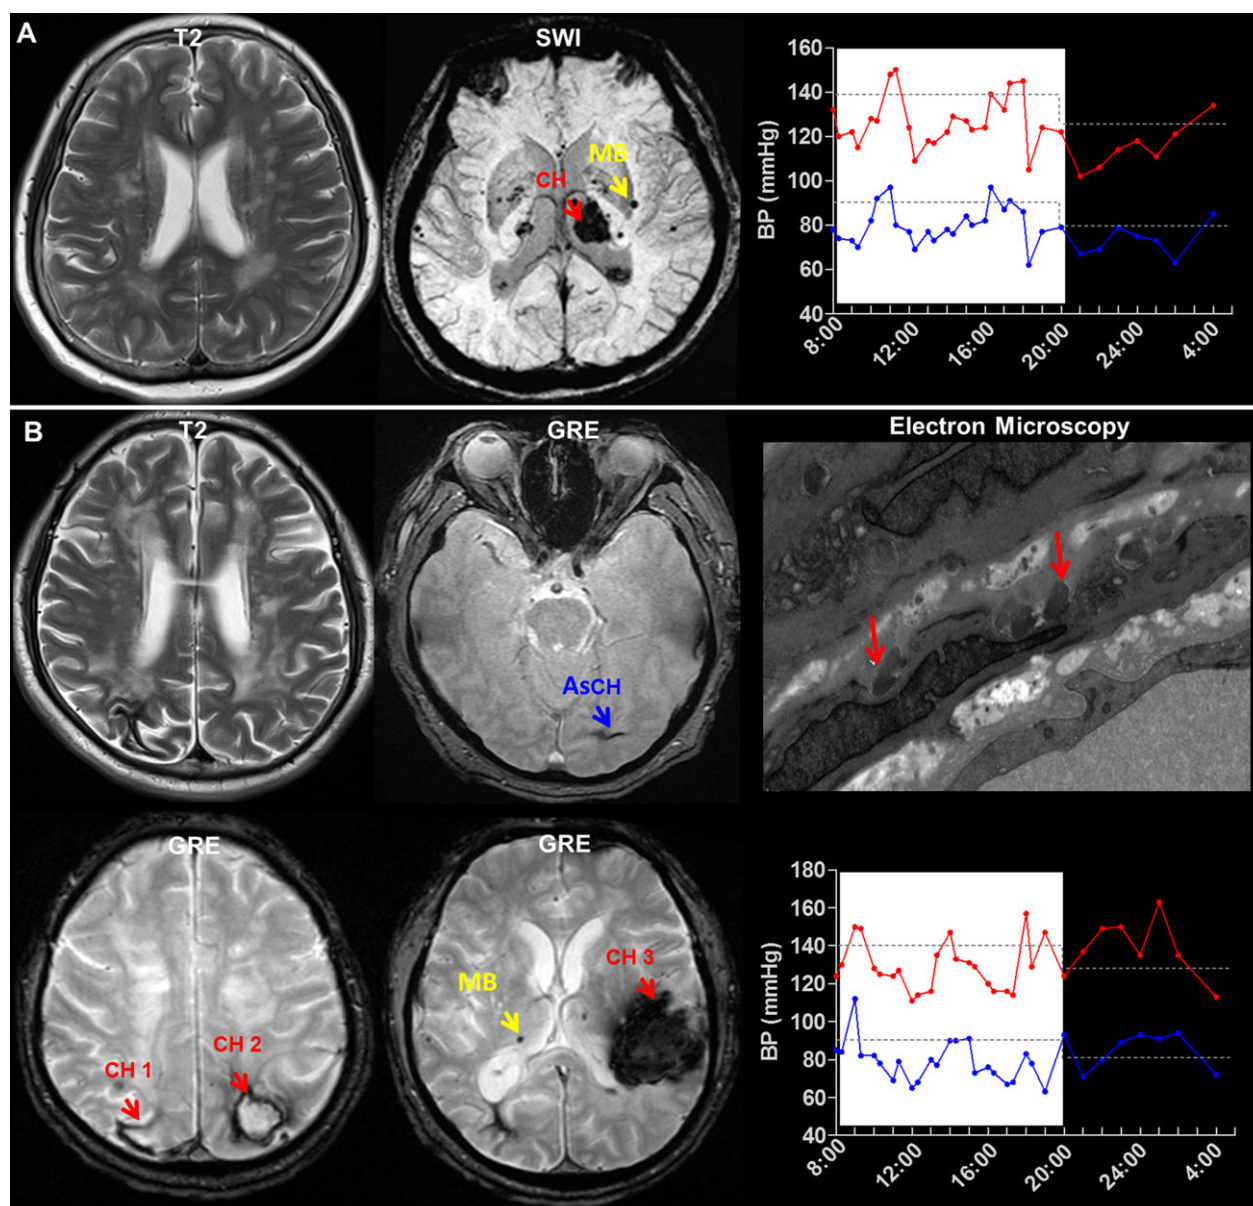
Spontaneous cerebral hemorrhage in two patients with CADASIL. (A) Patient 1 carried the Arg544Cys NOTCH3 gene mutation and showed multiple white matter lesions, lacunar infarcts, numerous microbleeds (MB), and a cerebral hemorrhage (CH) lesion in the left thalamus on brain MRI. Two episodes of high blood pressure (11:00 to 11:30 and 17:30 to 18:00) were found using an ambulatory blood pressure monitor. (B) Brain images show three symptomatic CH lesions (CH1, CH2, CH3) and one asymptomatic cerebral hemorrhage (AsCH) in the left occipital lobe of patient 2, who carried the CGCT insertion in the NOTCH3 gene; multiple white matter lesions, lacunar infarcts and microbleeds were also shown by MRI. A skin biopsy showed deposits of granular osmiophilic material in the basement membranes of smooth muscle cells. In addition, an ambulatory blood pressure monitor revealed nocturnal hypertension and occasional daytime hypertension.
